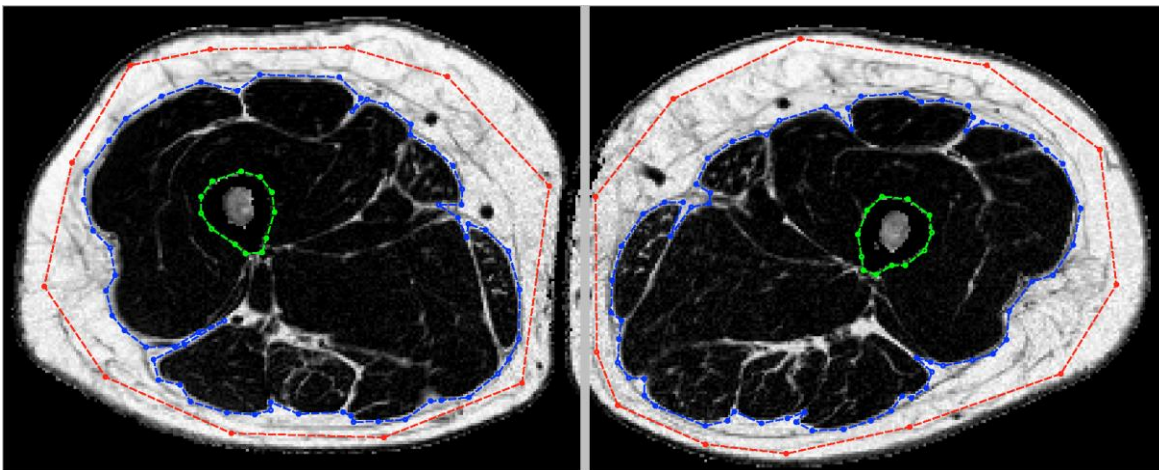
MRI of whole thigh CSA - week 12. Left side image is right thigh for IG subject. There has been a noticeable reduction in subcutaneous adipose tissue (white outer area).
